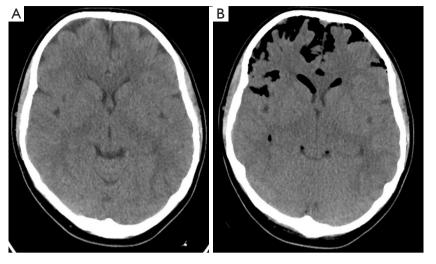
Comparative head CT imaging. (A) Initial CT without contrast at presentation demonstrating no intracranial pathology. (B) Subsequent CT without contrast on hospital day 1 demonstrating pneumocephalus. CT, computed tomography.
